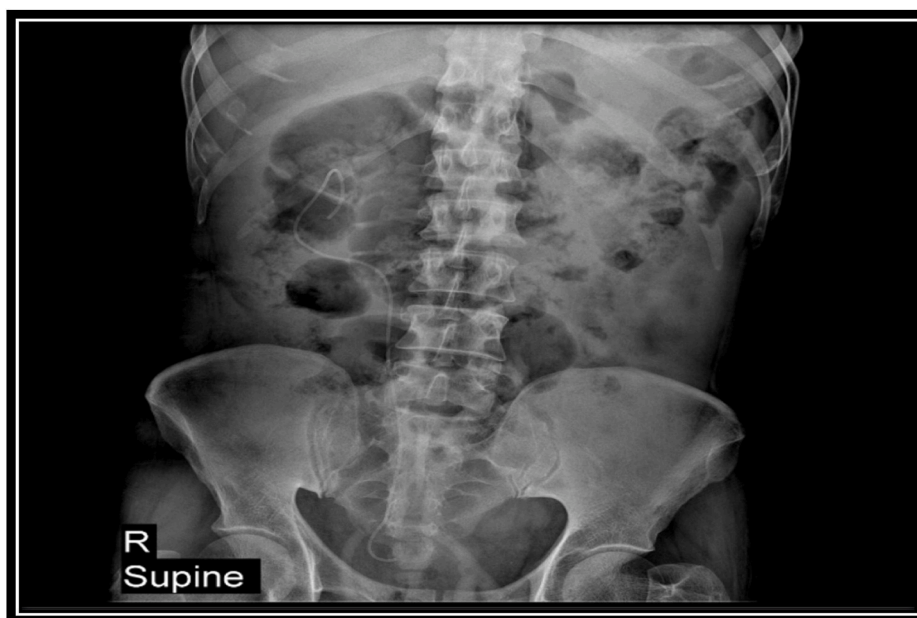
Post-op x-ray image of the KUB.
